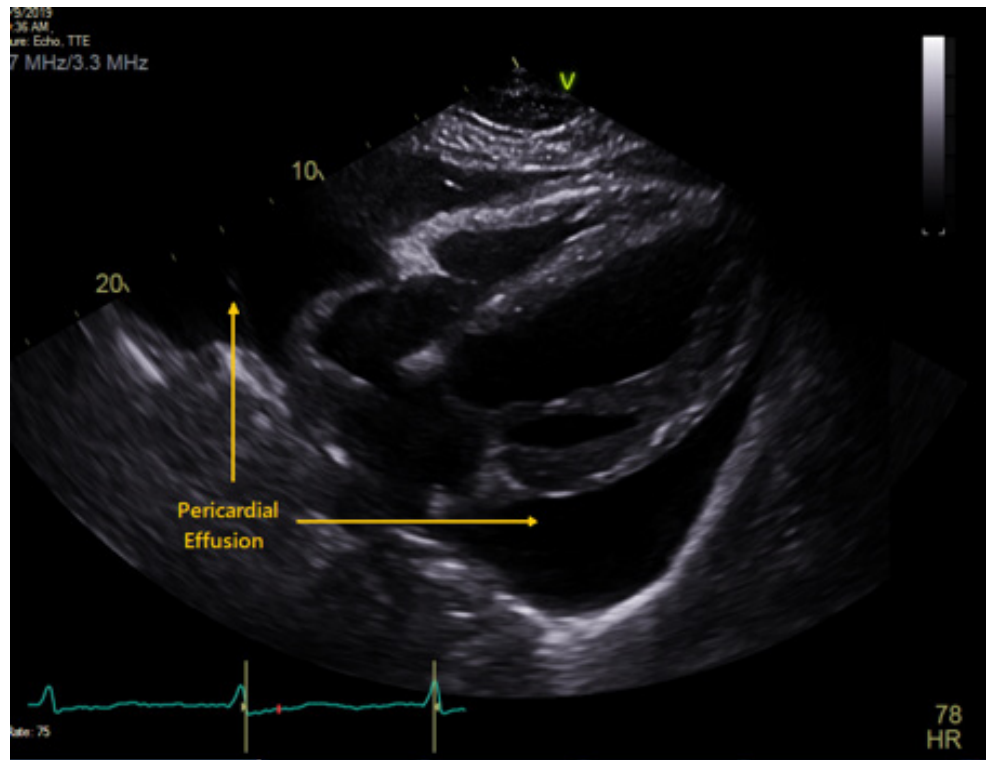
Parasternal view showing large pericardial effusion.
